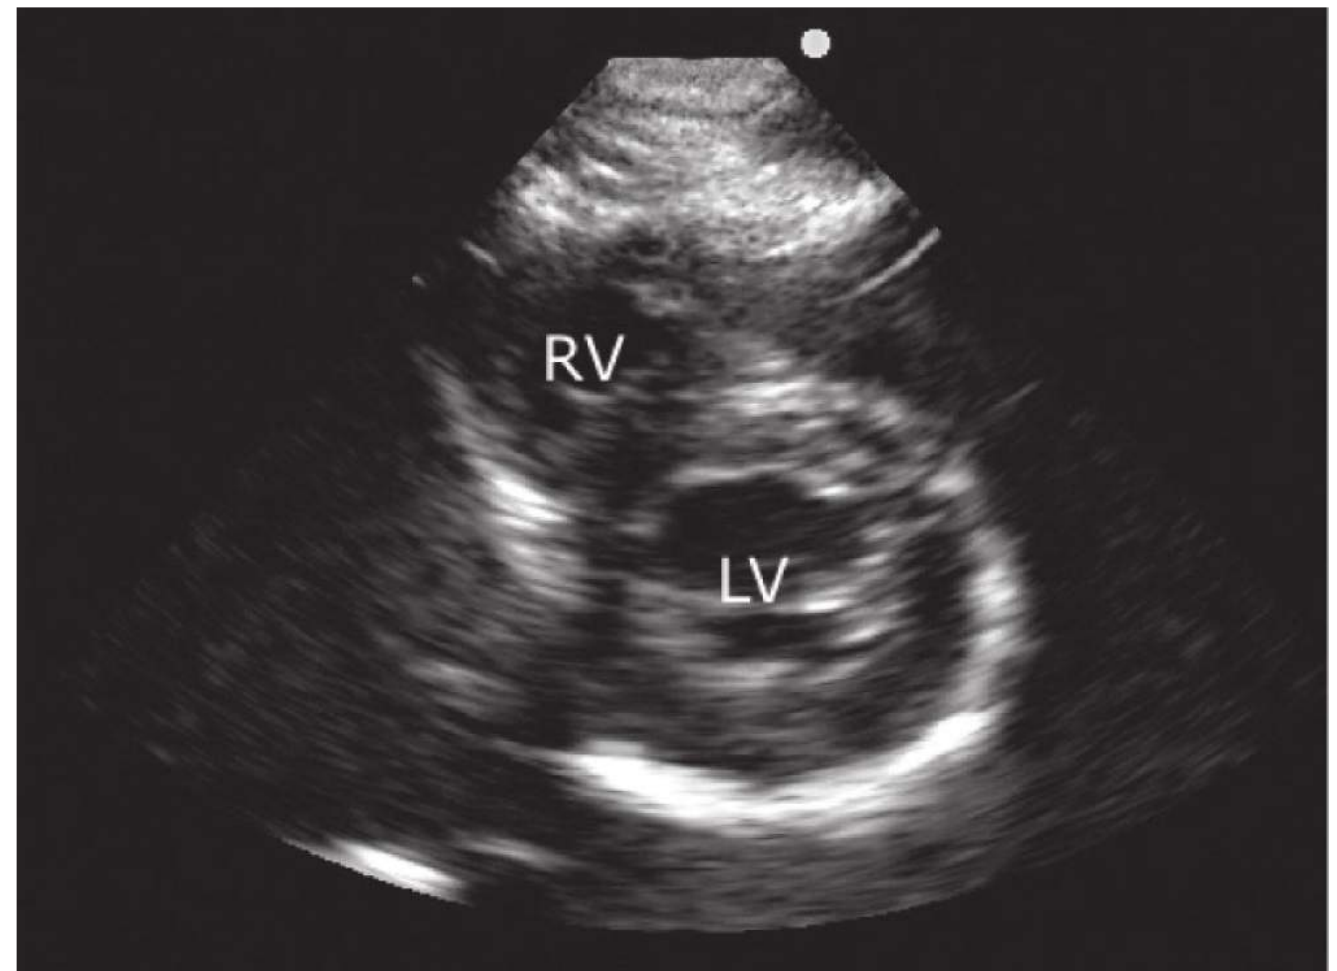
Parasternal short-axis view at the level of the papillary muscles of a normal heart. This marks the portion of the left ventricle immediately distal to the mitral valve, which is where left ventricular function is assessed. This view is also excellent for identifying regional wall motion abnormalities.
